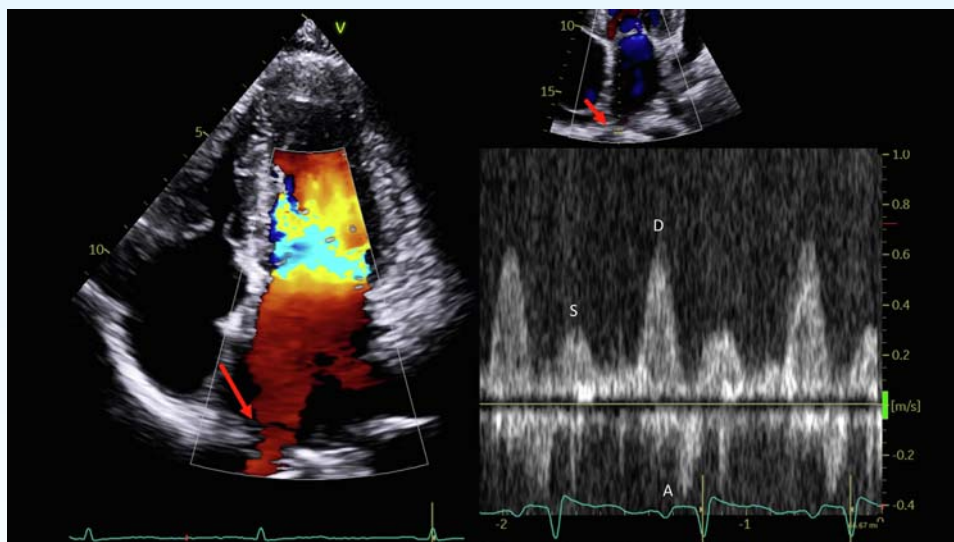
Color and spectral Doppler echocardiography of pulmonary vein (PV; red arrow). As shown in the *top image*, it is important to place the sample volume 1-2 mm into the PV. The pulsed-wave Doppler waveform shows a blunted systolic inflow (S), with higher velocity diastolic flow (D) and marked atrial reversal (A).
